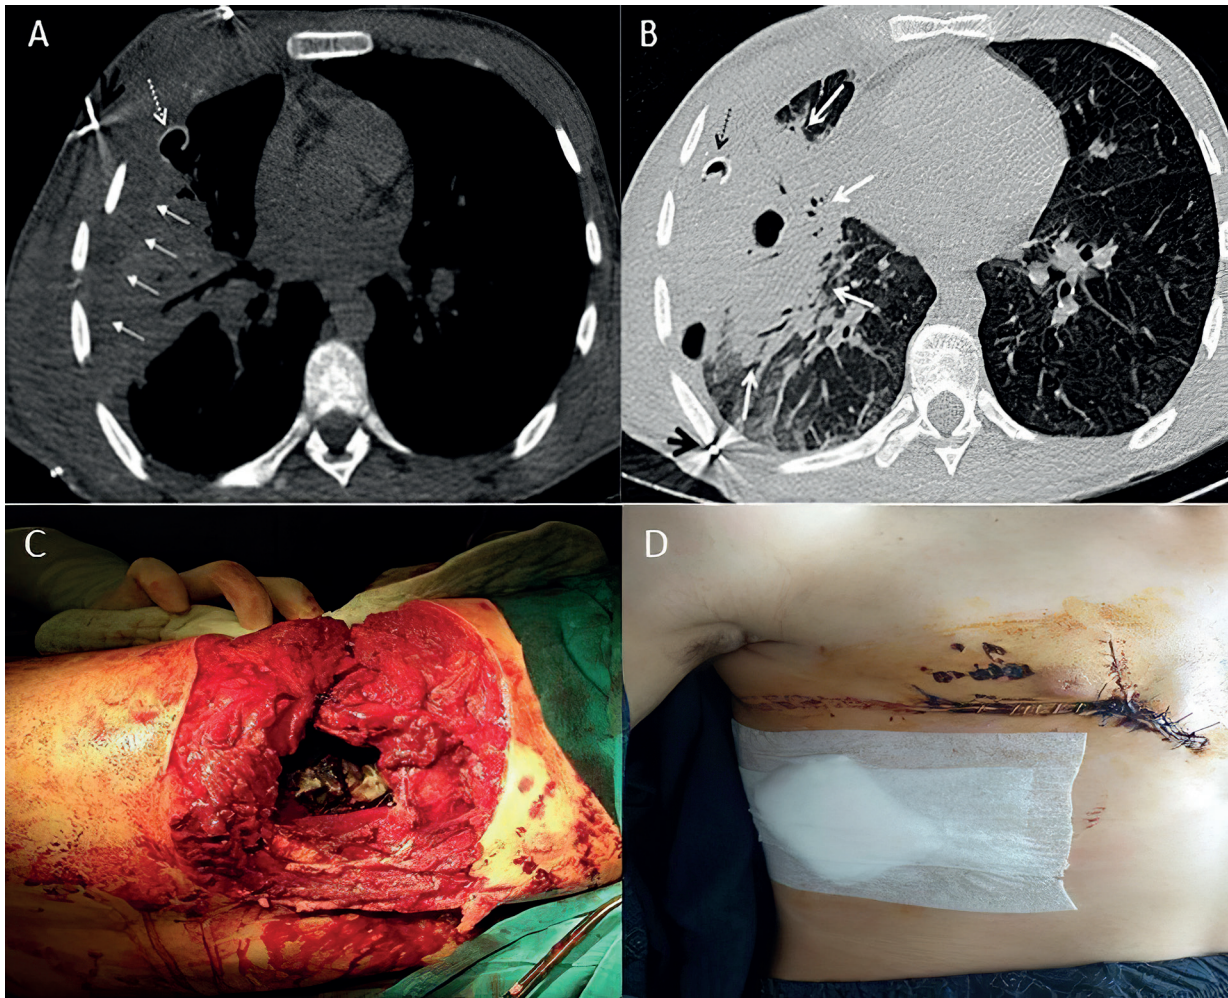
17-year-old male patient. Axial mediastinal (A) and parenchymal (B) window of thorax CT images reveal minimal hemothorax (thin white arrows), large area of contusion in the right lung (thick white arrows), thoracostomy tube (dashed arrow), bullet fragment (black arrow). Lung hemorrhage control, lobectomy not performed, no abdominal cardiac and diaphragm injury, skin flap application by sliding the latissimus dorsi defect area, posterolateral thoracotomy photograph (C). The area with the bandage where the chest tube was removed (D).
